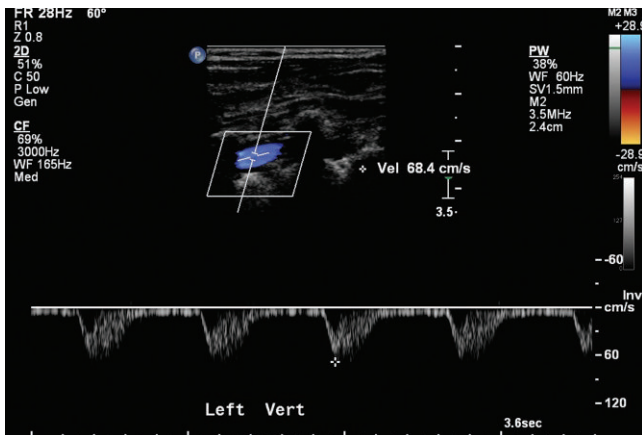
The vertebral artery color Doppler is blue, toward the transducer and toward the feet. The spectral Doppler is below the baseline, but the spectrum is inverted (Inv at right end of the scale). The direction of flow is therefore toward the transducer (+68.4 cm/s) and toward the feet. The flow is continuous toward the feet indicating a complete subclavian steal.
